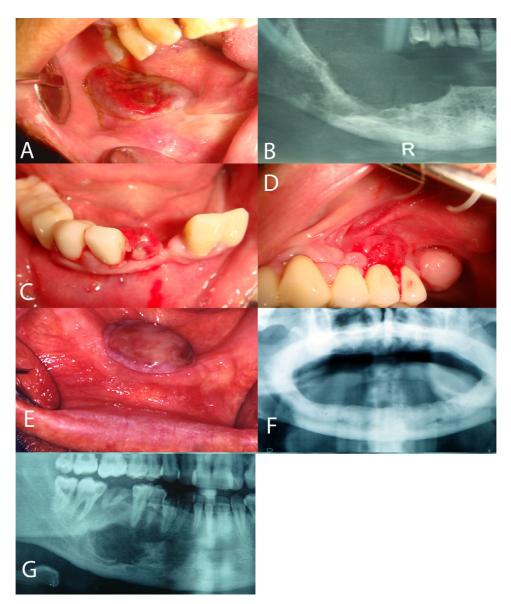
Patient 1: A, Clinical appearance of the lesion during intraoral examination. B, Orthopantomography in the pretreatment phase. Even if the lesion is exophytic in nature, it damages the underlying bone. Patient 2: C, Clinical appearance of the lesion involving the lower jaw during intraoral examination. D, Clinical appearance of the lesion involving the upper jaw during intraoral examination. Multiple lesions were present in this subject. Patient 3: E, Clinical appearance of the lesion involving the lower jaw during intraoral examination. F, Orthopantomography at the time of diagnosis. The lesion was exophytic in nature and a normal cortical bone was detected via panoramic radiographs. Patient 4: G, Orthopantomography in the pretreatment phase showed an altered bone structure of the jaw, but no swallowing of the mandible could be clinically noted.
